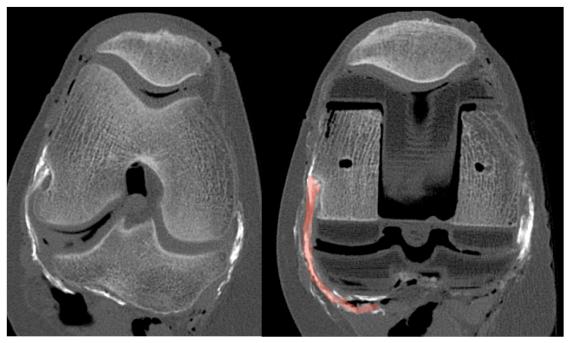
CT scan imaging of the popliteus tendon and MCL preoperatively (left) in a modified transverse plane. Postoperatively (right) the popliteus (red) and the MCL (white) are visible as well as their relationships with the bone and implant.
